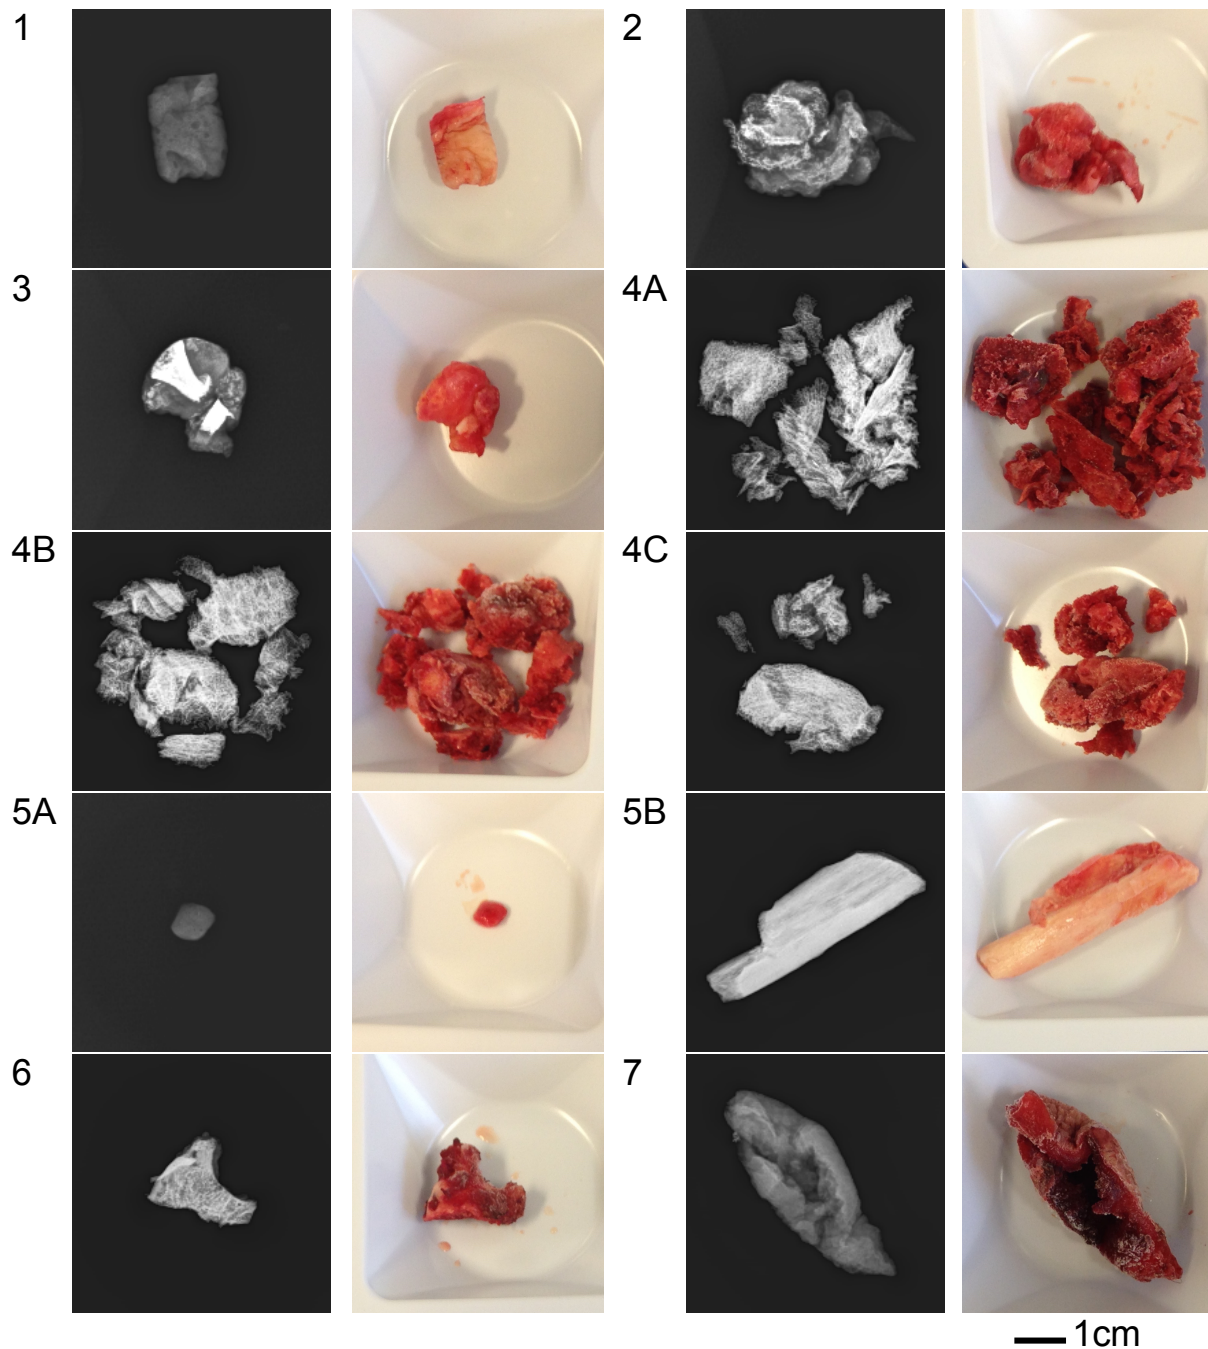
Contact radiographs and photographs of all of the samples of human HO. It is clear that there is a great deal of variability with cortical, cancellous, and hybrid morphologies demonstrated to different degrees within and between samples. Scale: each radiograph / photograph is 5cm across.
